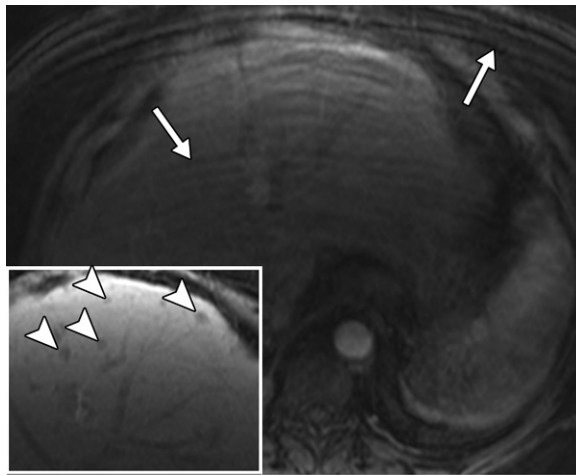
Trade-offs in imaging hypervascular metastases with gadoxetate in a 59-year-old woman with metastatic melanoma. Axial MR image in the arterial phase is markedly degraded by transient arterial phase motion (arrows), limiting the evaluation of hyperenhancing metastases. However, the HBP image (inset) clearly shows numerous hypointense liver metastases (arrowheads). We prefer gadoxetate as the contrast agent for liver MRI in patients with hypervascular metastases.
